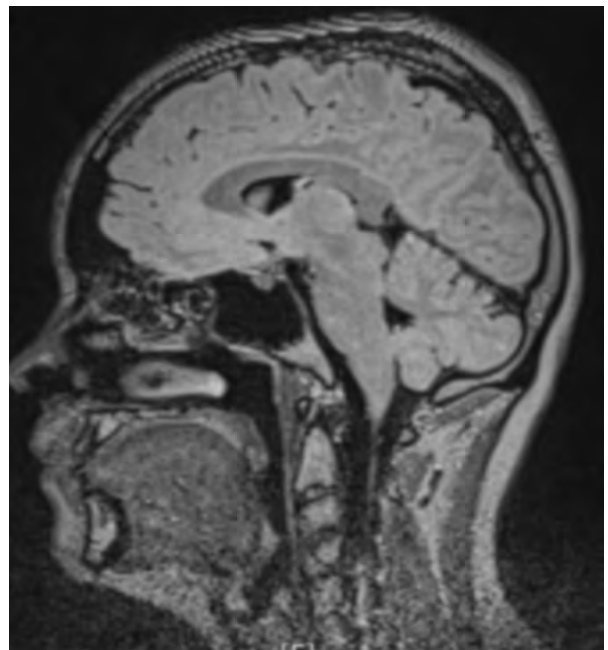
Midline sagittal T2-weighted MRI: typical lesions in corpus callosum
